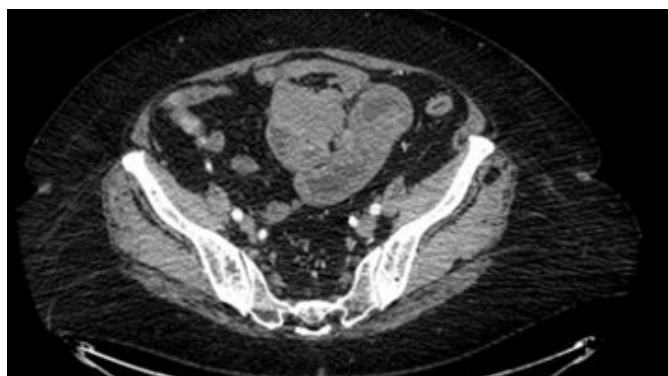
CT enterography demonstrating mass lesion.
